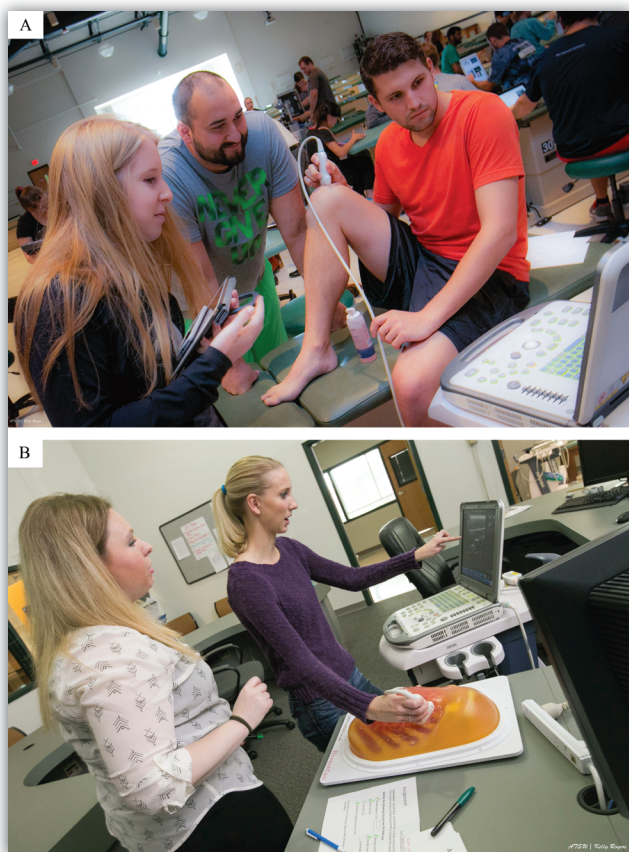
Medical Students Learning Ultrasound Imaging during Ultrasound Laboratories.
